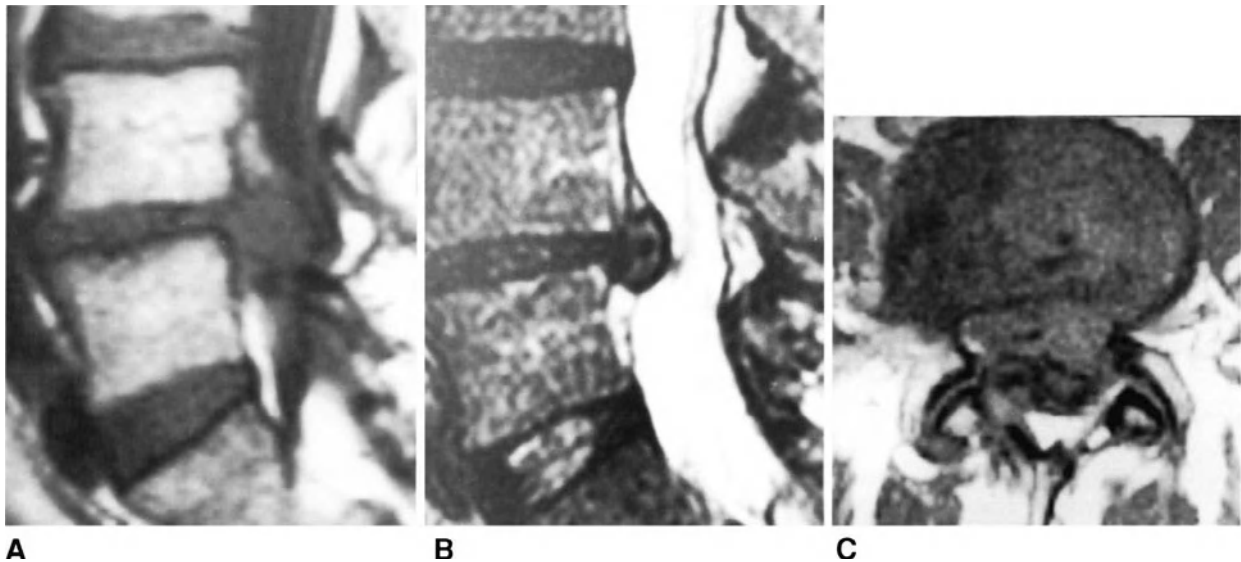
Retroligamentous extruded L4-L5 disc herniation. Spin-echo T1-weighted sagittal image (A), turbo spin-echo T2-weighted sagittal image (B) and spin-echo T1-weighted axial image (C). A mass of disc tissue is visible in front of the disc and behind the posterior longitudinal ligament. A thin pedicle of tissue joins the mass to the parent disc.
